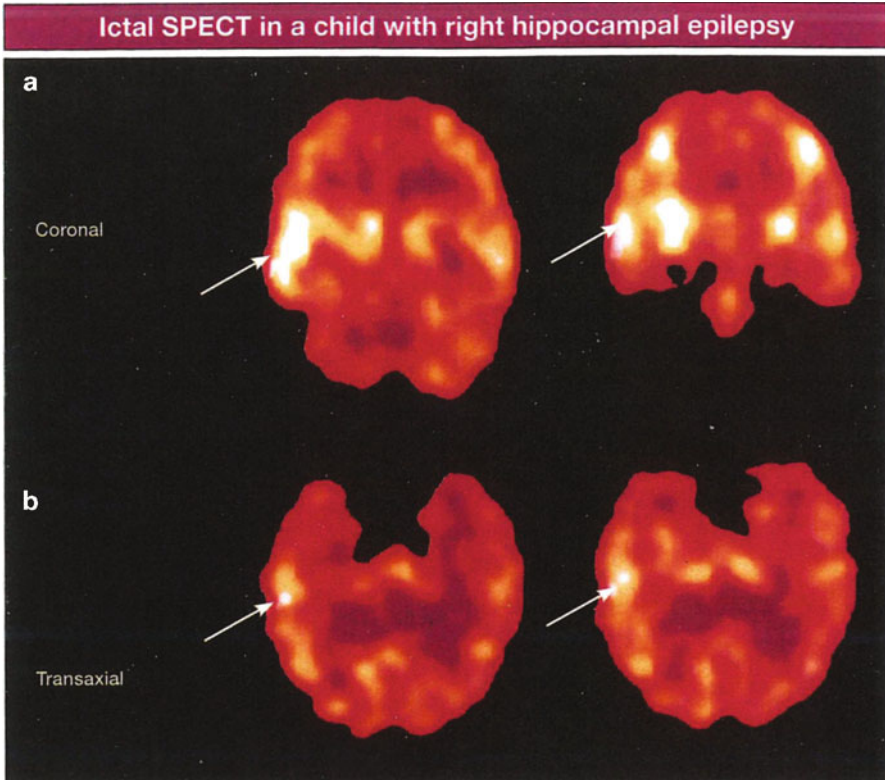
Coronal (a) and axial (b) ^{99m}Tc HMPAO SPECT images with increased right anterior temporal lobe increased perfusion. With kind permission of Springer Science+Business Media: *Epileptic Syndromes and Their Treatment* 2010, p. 167, Pannaylotopoulos, C., Fig. 6.11
